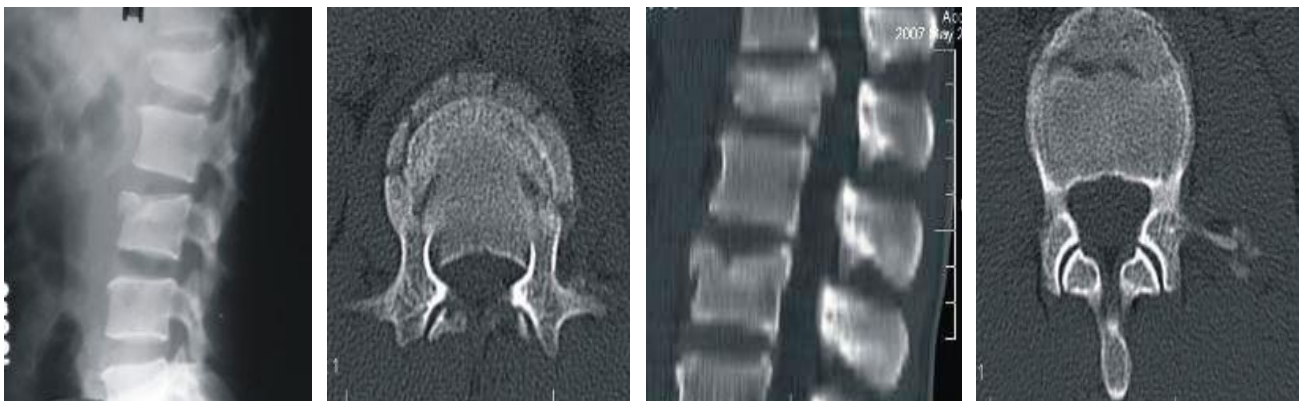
Radiograph lateral view (6a) shows compression fracture of L1 vertebral body and anterosuperior triangular fracture of L3 vertebral body and CT axial and sagittal (6c) images in same patient revealed L1 burst fracture with retropulsion of fracture fragment (6b) into the spinal canal and also transverse process fracture (6d).
